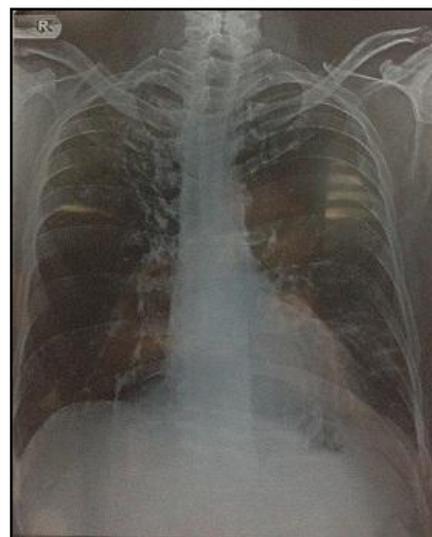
X-ray chest PA view showing ill-margined opacities and prominent bronchovascular markings in both the lung fields
